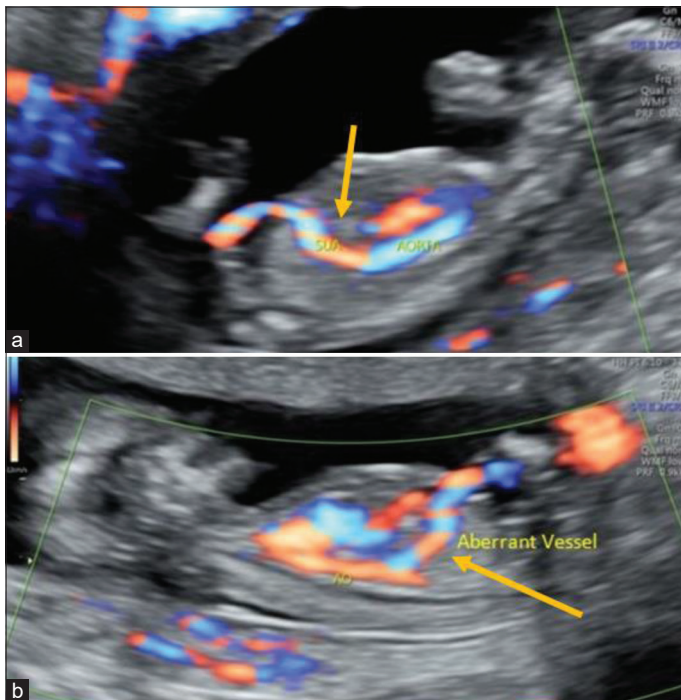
(a and b) ultrasound with color Doppler in sagittal view. Arrows showing an aberrant, large vessel arising from the aorta tracking anteriorly towards the umbilical cord. Beyond its origin, the aorta was hypoplastic
